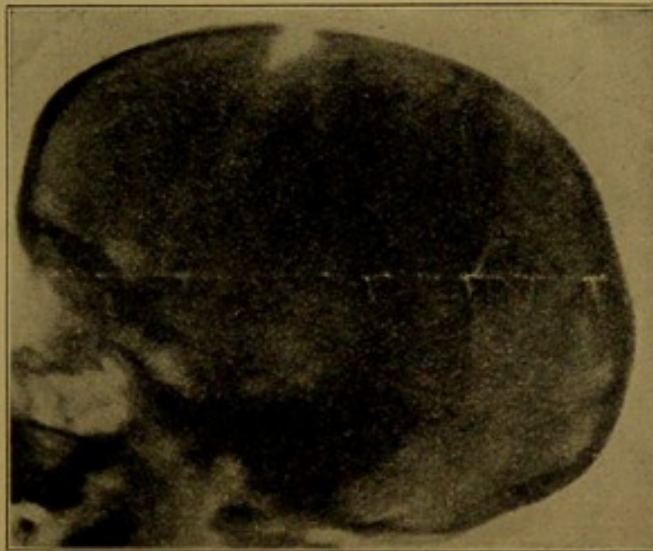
X-ray photograph, showing separation of coronal suture in a girl aged 11 years, the subject of acquired hydrocephalus. (Bruce and Cotterill.)
